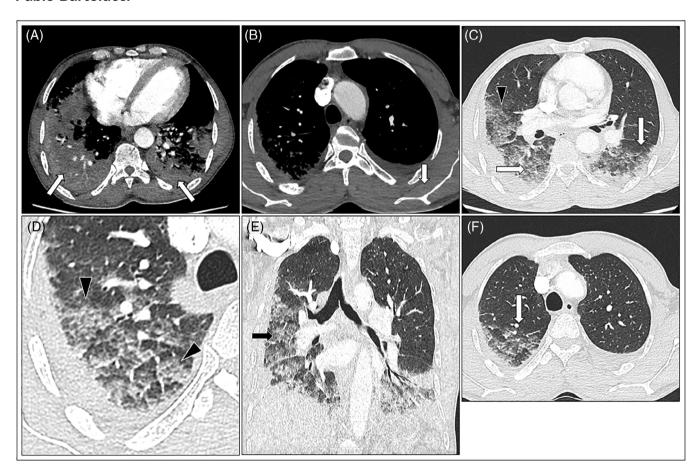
CT scan of the chest: Acute chest syndrome and Covid-19-induced pneumonia. A, Axial image of chest obtained with a soft-tissue windows at the level of the lower lobes evidenced areas of consolidation located at the posterior part of the lung (arrows). B, An axial image with the same windowing obtained at the upper part of the lungs showed a right small pleural effusion in the upper part of the great pleural cavity (arrow). C, Axial image located at the same level as A with lung windows evidenced areas of ground-glass opacities (arrows) in the lower lungs with regards to areas of consolidation, but also in the middle lobe (arrowhead) D, and in the upper right lobe. E, Coronal reconstruction confirmed areas of groundglass opacities (arrow) and areas of consolidation with air bronchograms (arrowhead). F, Magnification of a CT image with lung windows acquired at the middle part of the lungs showing a crazy-paving pattern with ground-glass opacities and interlobar septal thickening (arrowhead)
